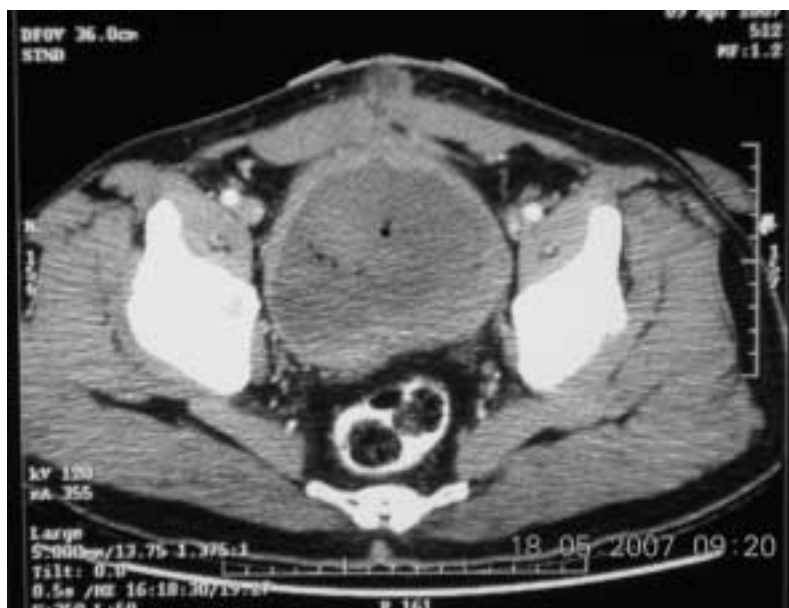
Staging CT scan demonstrated an organ confined lesion, with no lymphadenopathy. The bladder was completely filled with the lesion, interfaced with air filled cavities.
